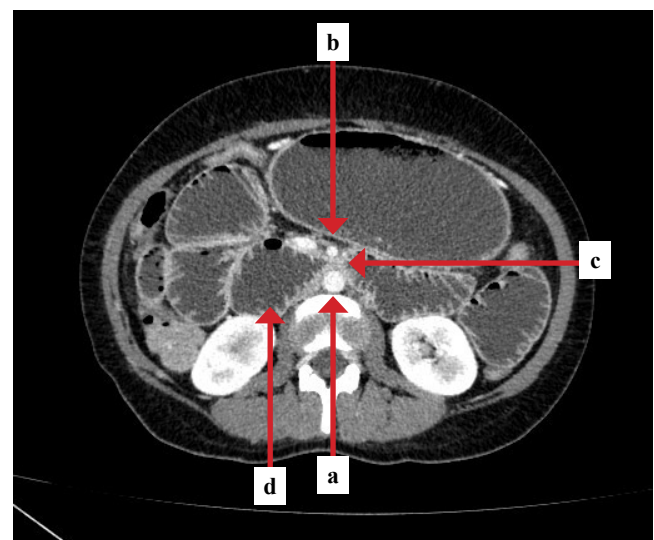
CT scan of the abdomen demonstrating compression of the duodenum between the aorta and SMA; a) aorta, b) SMA, c) duodenum; d) small bowel obstruction distal to this compression point can be seen
